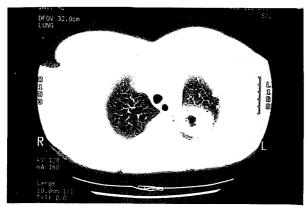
The chest CT performed at our ER showed a cavitary lesion in the left upper lobe, posterior segment.
